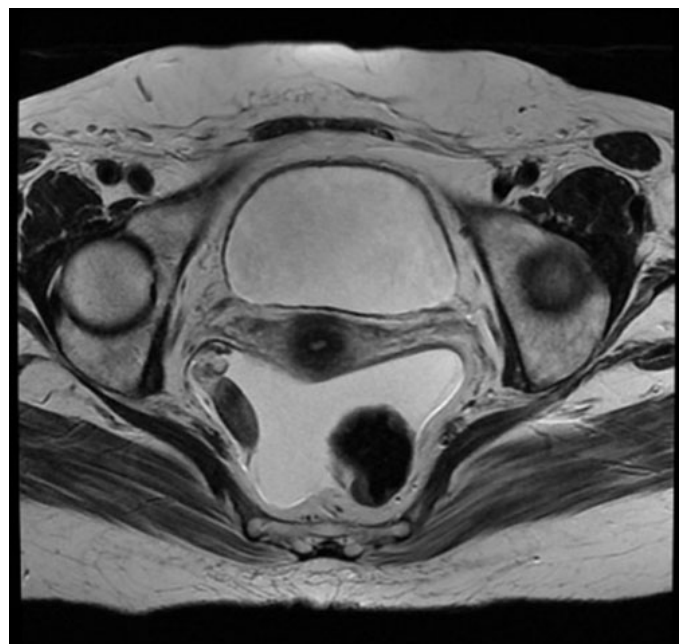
T2-weighted axial MRI showing the right ovary without abnormality.
